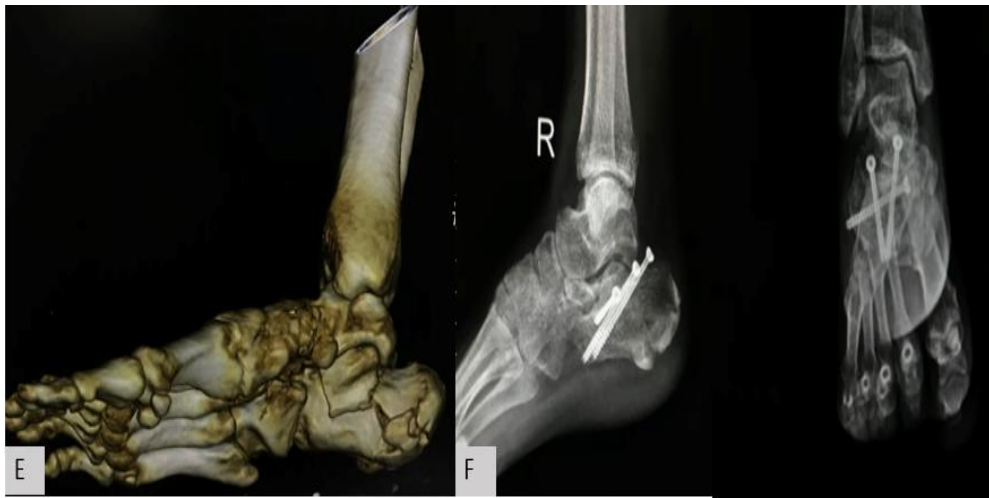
E. 3-D VRT image revealing the comminuted nature of calcaneal fracture with intra-articular extension. F. Follow up post operative x-ray lateral and AP view of ankle showing well reduced fracture with metallic implants seen *insitu*.
